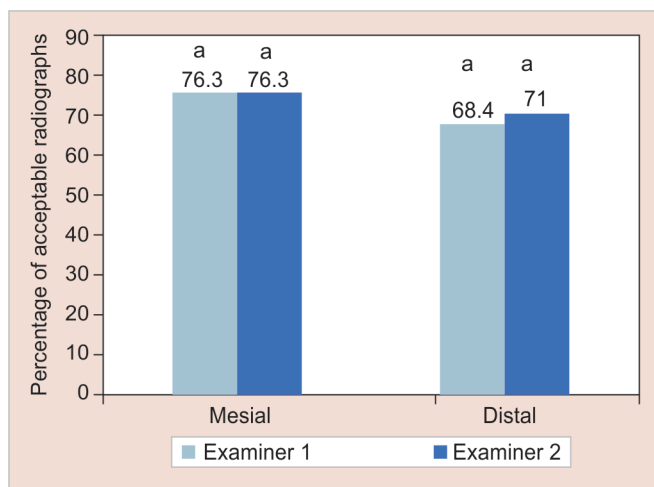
Graph showing the percentage of acceptable premolar radiographs determined by the two examiners. The same letters indicate no significant difference between bars ($p > 0.05$)
